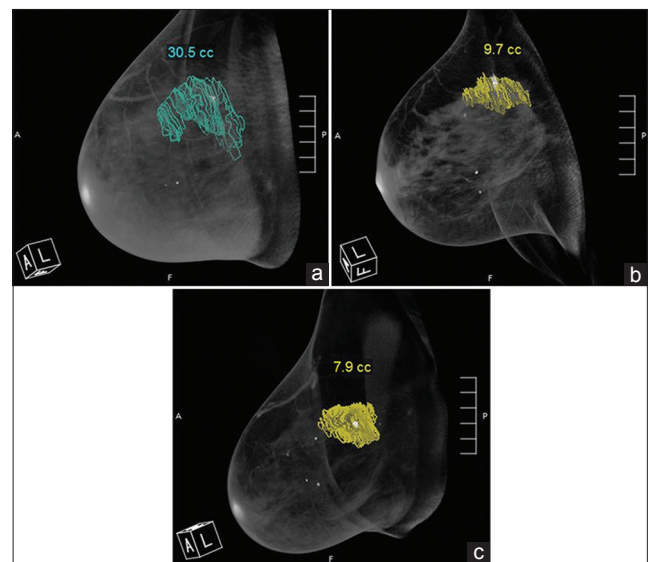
48-year-old woman diagnosed with invasive ductal carcinoma. Radiologist segmented the tumor from multiple coronal images. Volume-rendered (3-D) breast CT images show the tumor volume obtained at (a) pre-treatment, (b) mid-treatment, and (c) post-treatment.
